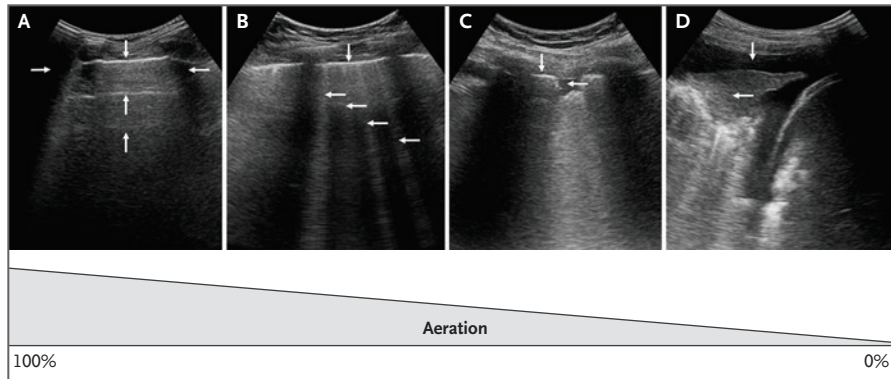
Ultrasound Images of the Lung According to the Level of Aeration.
